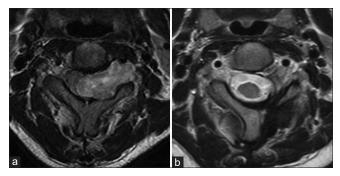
Pre- and post-operative T2-weighted axial magnetic resonance imaging (MRI) of case 3. (a) Preoperative MRI shows cervical extramedullary tumor with dumbbell extension at the C2/C3 level on the left side, (b) Postoperative MRI shows the intentional posterior removal of the tumor to the vertebral artery line
